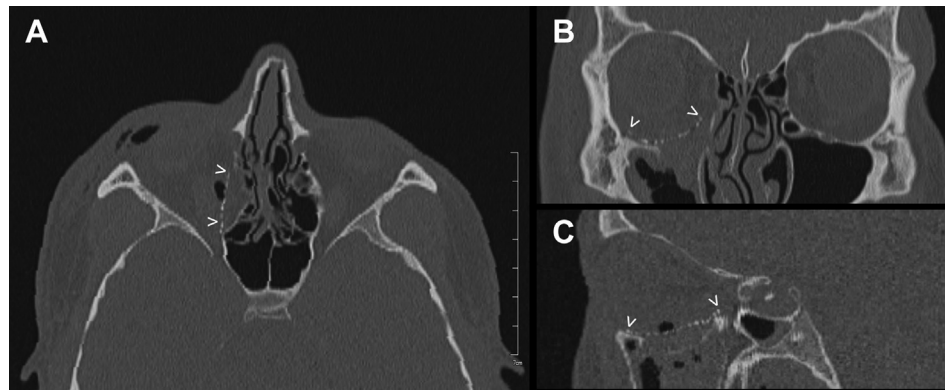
Postoperative computerized tomography reveals a clearly visible position of the implant thanks to titanium cube marking by ultrasound technique. A – axial view, B – coronal view, C – sagittal view. Arrows indicate implant position in the right orbit.
